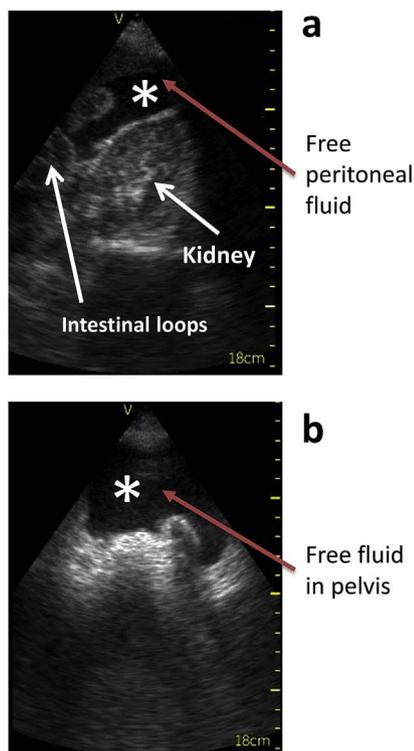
Focused assessment with sonography for trauma (FAST) performed on 35 years old male admitted 24 h after involvement in motorcycle accident. The study is performed by treating physicians and reviewed by radiologist in Israel. Large amount of free intraperitoneal fluid (*) was demonstrated in right upper quadrant (a) and in suprapubic view (b).
